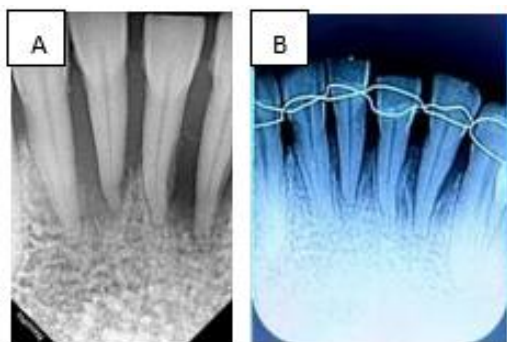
Radiograph view A. Before initial treatment B. After 6 months of periodontal therapy
